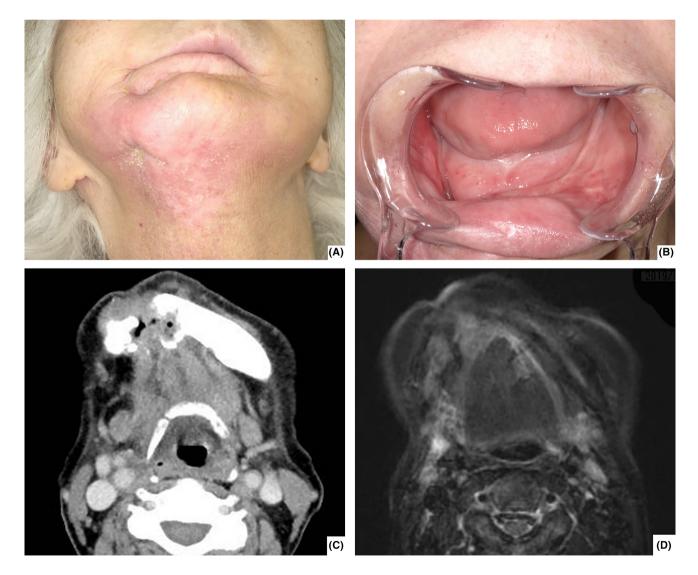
(A, B) A photograph showing the patient's intra- and extraoral appearance after 13 cycles of nivolumab treatment (C, D) Contrast-enhanced CT and STIR image showing no residual tumor in the mandible.
